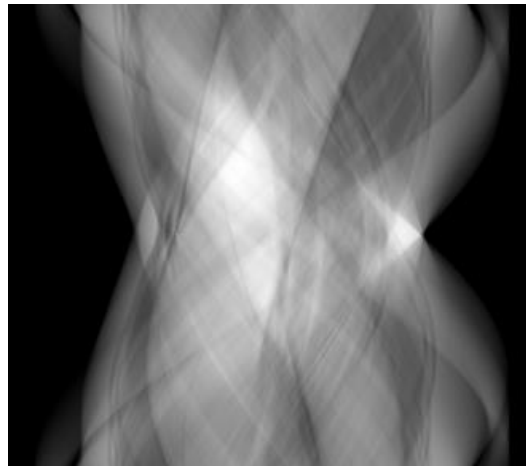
A sinogram of the activity maps of frame 28 obtained during forward projection step using Discovery PET/CT 710 scanner model.
